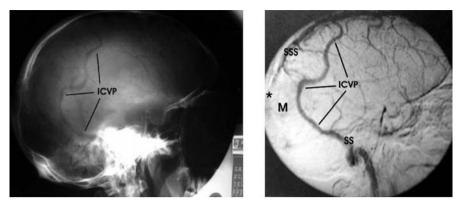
Parasagittal meningioma with Type VI invasion in the posterior third of the sinus. *Left*: Plain X-ray, lateral view, showing a voluminous intraosseous collateral venous pathway (ICVP). *Right*: venous-phase DS angiogram, lateral view, demonstrating the collateral venous circulation from the Superior Sagittal Sinus (SSS) to the sigmoid sinus (SS). Note complete occlusion (*asterisk*) of the SSS by the meningioma (M)
